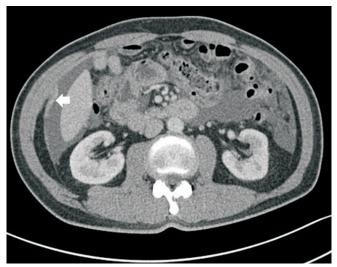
Abdominal computed tomography showed a moderate amount of ascites, with some part of the peritoneum being irregularly thickened (arrow).
